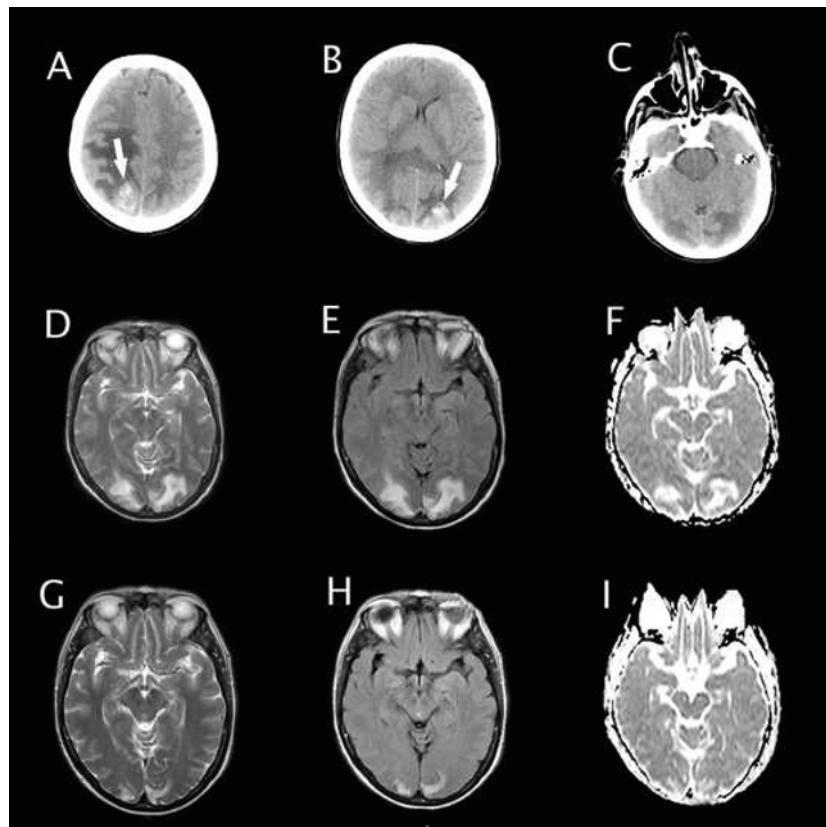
Imaging results in a 47-year old woman with RPLS. A-C. CT scan. White matter hypodensity in the right fronto-parieto-occipital and the left parieto-occipital lobe, together with a right parietal and left parieto-occipital haemorrhage. D-F. MRI performed on the same day. Increased white matter signal on T2 (D), FLAIR (E) and ADC (F) sequences with the same distribution as white matter hypodensity on CT. G-I. MRI 3 months later. Partial resolution of the MRI lesions.
